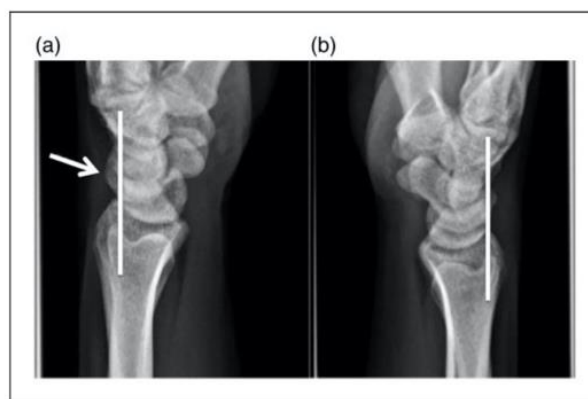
Radiographic evaluation of the posterior scaphoid subluxation: dorsal displacement of the proximal pole of the scaphoid with respect to its radial fossa and the posterior horn of the lunate is seen in static SL instability (a) in the lateral view. This displacement does not appear in the absence of instability (b).
